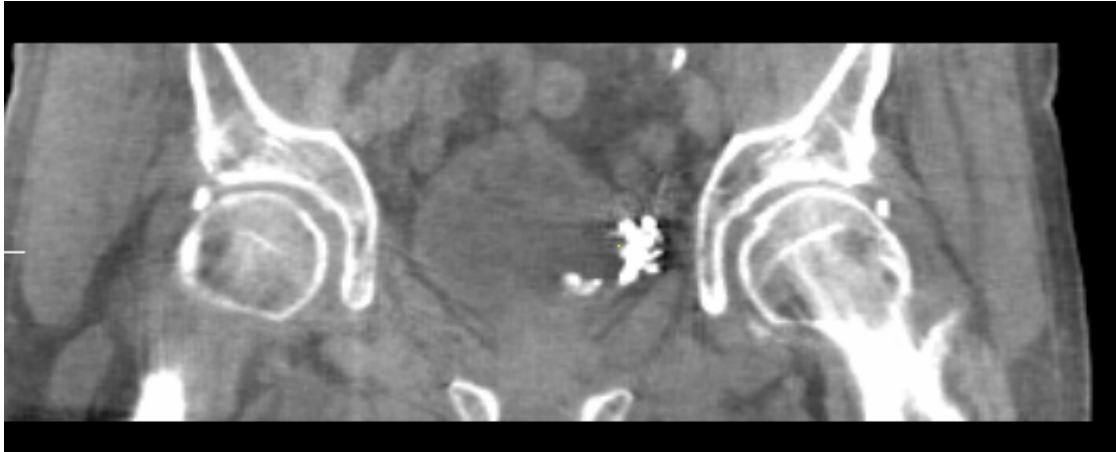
Coronal view of a CBCT image using preset Prostate M10 Fast.
